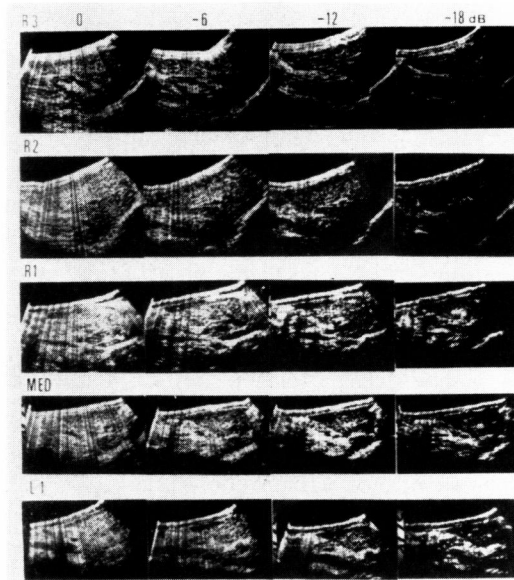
Sagittal scans of upper abdomen by sensitivity graded tomogram pairs. They are taken from the upper abdomen of a normal individual on five parallel sagittal planes at 6 dB steps. From top to bottom; R₃, rt ventral axillary line, R₂, rt mammary line, R₁, rt parasternal line, MED, median line and L₁, lt, parasternal line, respectively. Internal echoes of the liver disappeared following attenuation of -18 dB of the equipment sensitivity
